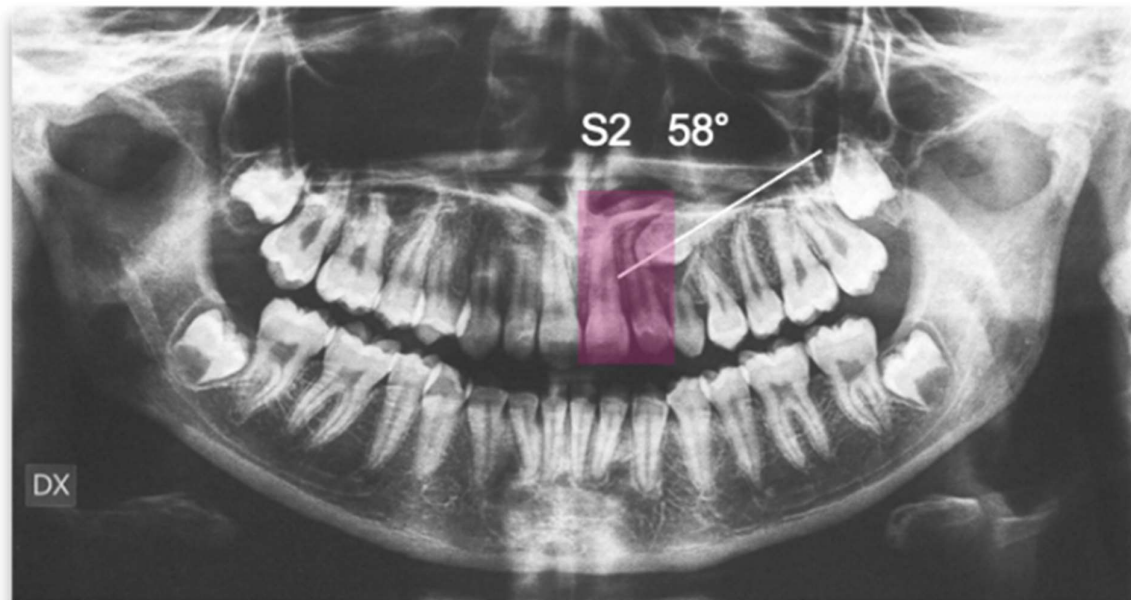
Pre-treatment panoramic X-ray with the evaluation of alpha angle and sector according to the Ericson and Kurol classification.
